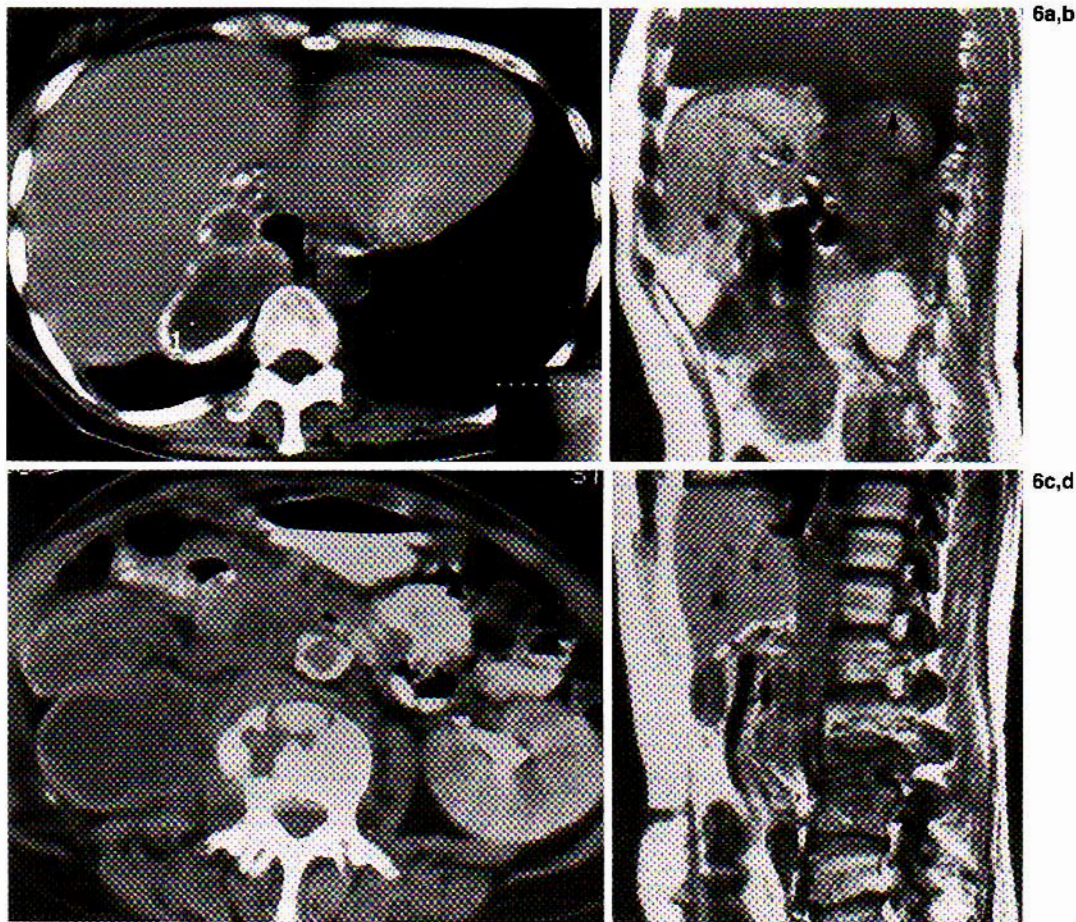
Extrahepatic extension of a hepatic posterior mass. CT scan (a) and T1-weighted image (b) (with cardiac gating) show the transdiaphragmatic extension (arrow, b). CT scan (c) and T1-weighted image (d) (with cardiac gating) show retroperitoneal extension with involvement of the third and fourth lumbar vertebrae.
